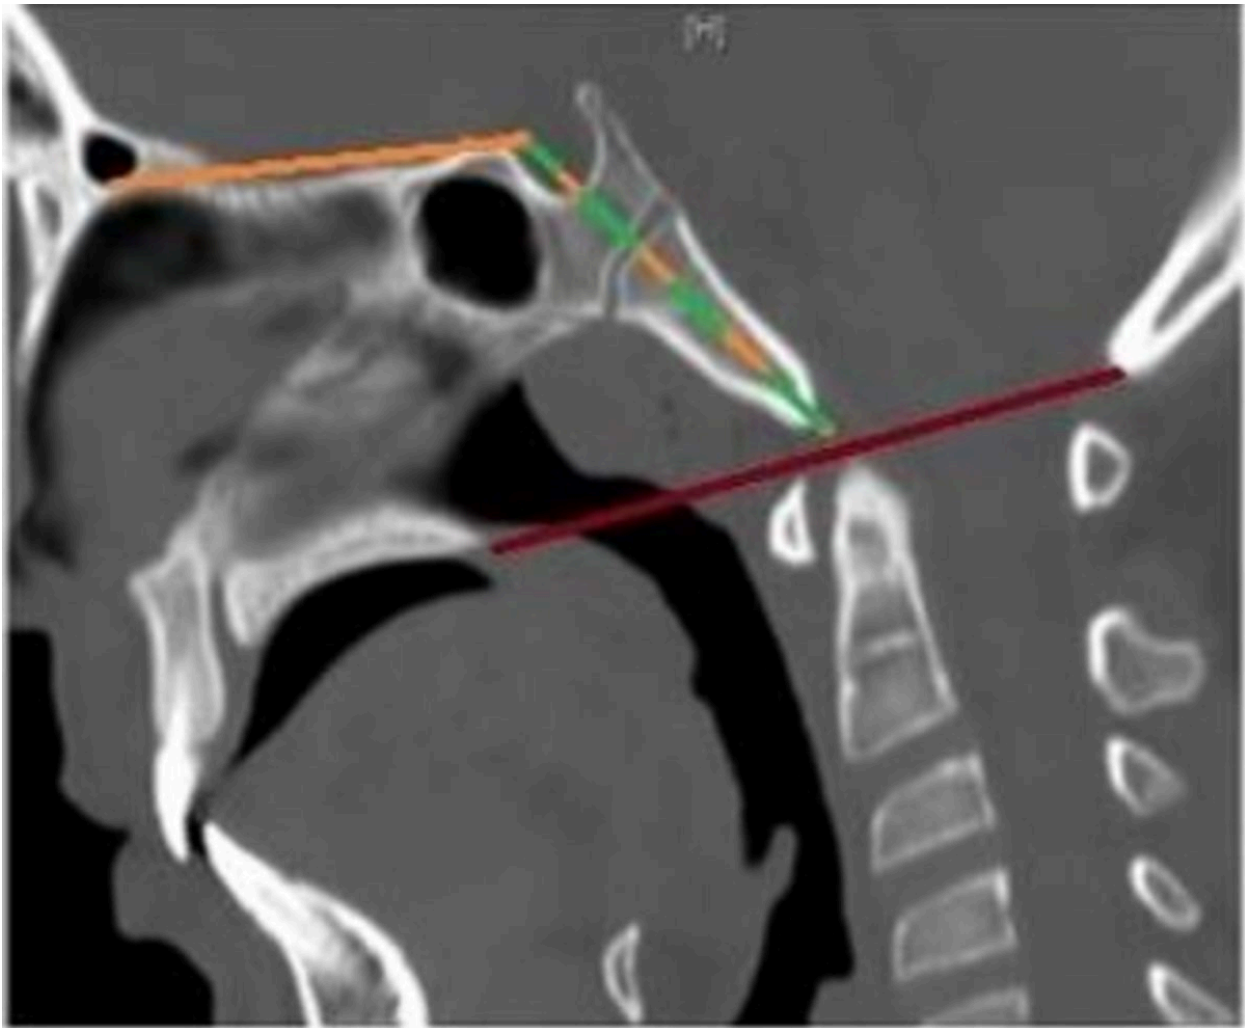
CT saggital section depicting the various lines used in the assesing the craniovertebral junction anatomy. welcher basal angle(orange) chamberlain angle(red) wackenheim clivus baseline(green)
